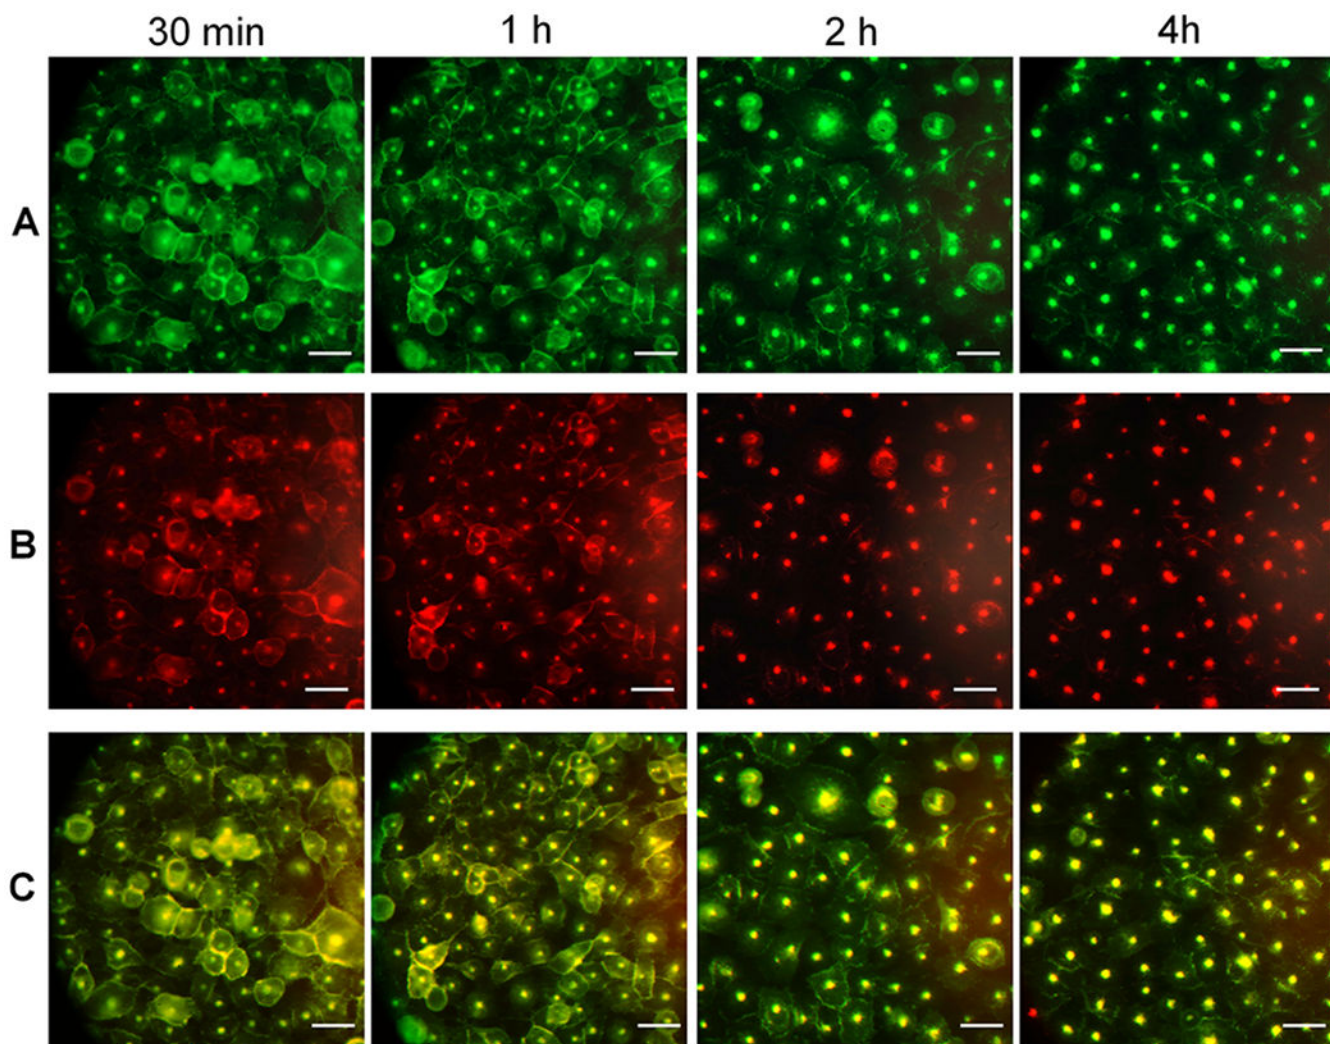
Time-dependent images of PSMA(+) PC3-PIP cells in pretargeted drug delivery using $F(ab')_2(TCO)_8(AF-488)_2$ and $ALB(DM1)_{3,3}(PEG_4-Tz)_{10}(Rhod)_2$. Panel A: Localization of the first component, $F(ab')_2(TCO)_8(AF-488)_2$, over the time after treatment with the drug delivery component (postdrug treatment time 30 min, 1, 2, 4 h). Panel B: Localization of the second drug delivery component, $ALB(DM1)_{3,3}(PEG_4-Tz)_{10}(Rhod)_2$, over the time after the treatment. Panel C: Merged images of corresponding green and red channels. (Scale bar: 100 μM .)
